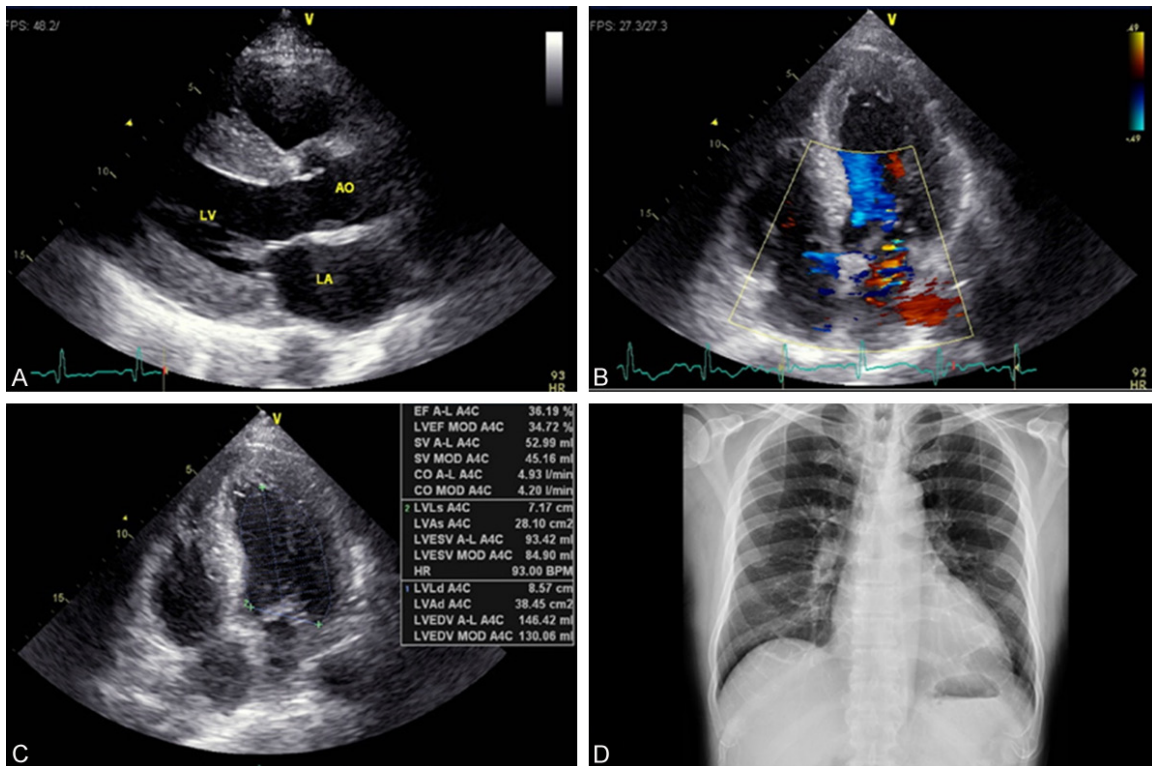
Ultrasonography scanning and X-ray examination at outpatient clinic before Eefooton treatment. The heart ultrasonography exhibited that patient had sinus rhythm, left atrial enlargement (A), and left ventricular hypertrophy (B, C). A left ventricular hypertrophy examined by the X-ray (D).
